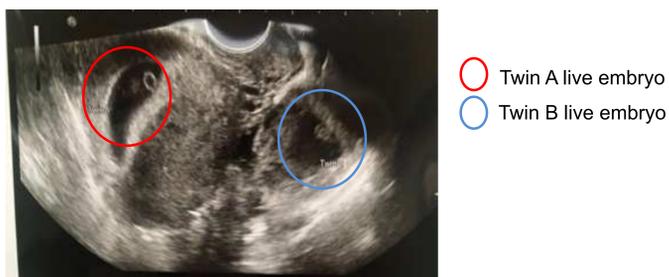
Ultrasound showing heterotopic pregnancy
